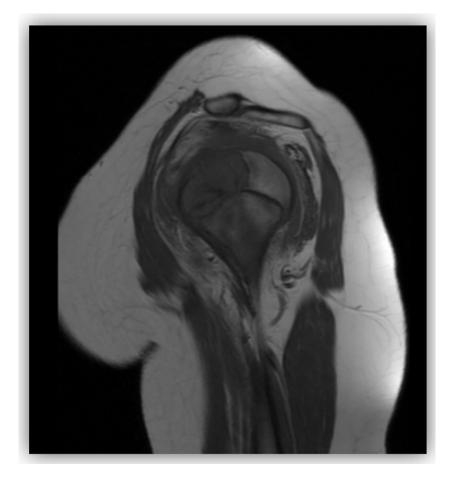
Magnetic resonance imaging of left shoulder of a skeletally immature patient before surgery.
